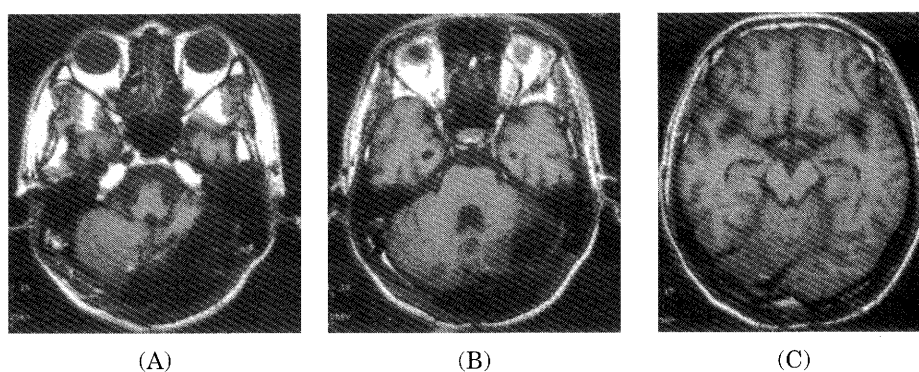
Post-operative MRI showed partial excision of the left cerebellar hemisphere.
